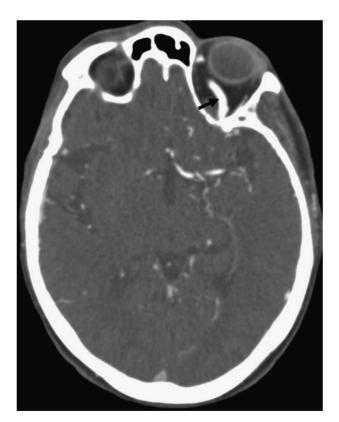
CT angiography demonstrates enlargement of the left superior ophthalmic vein (arrow).
